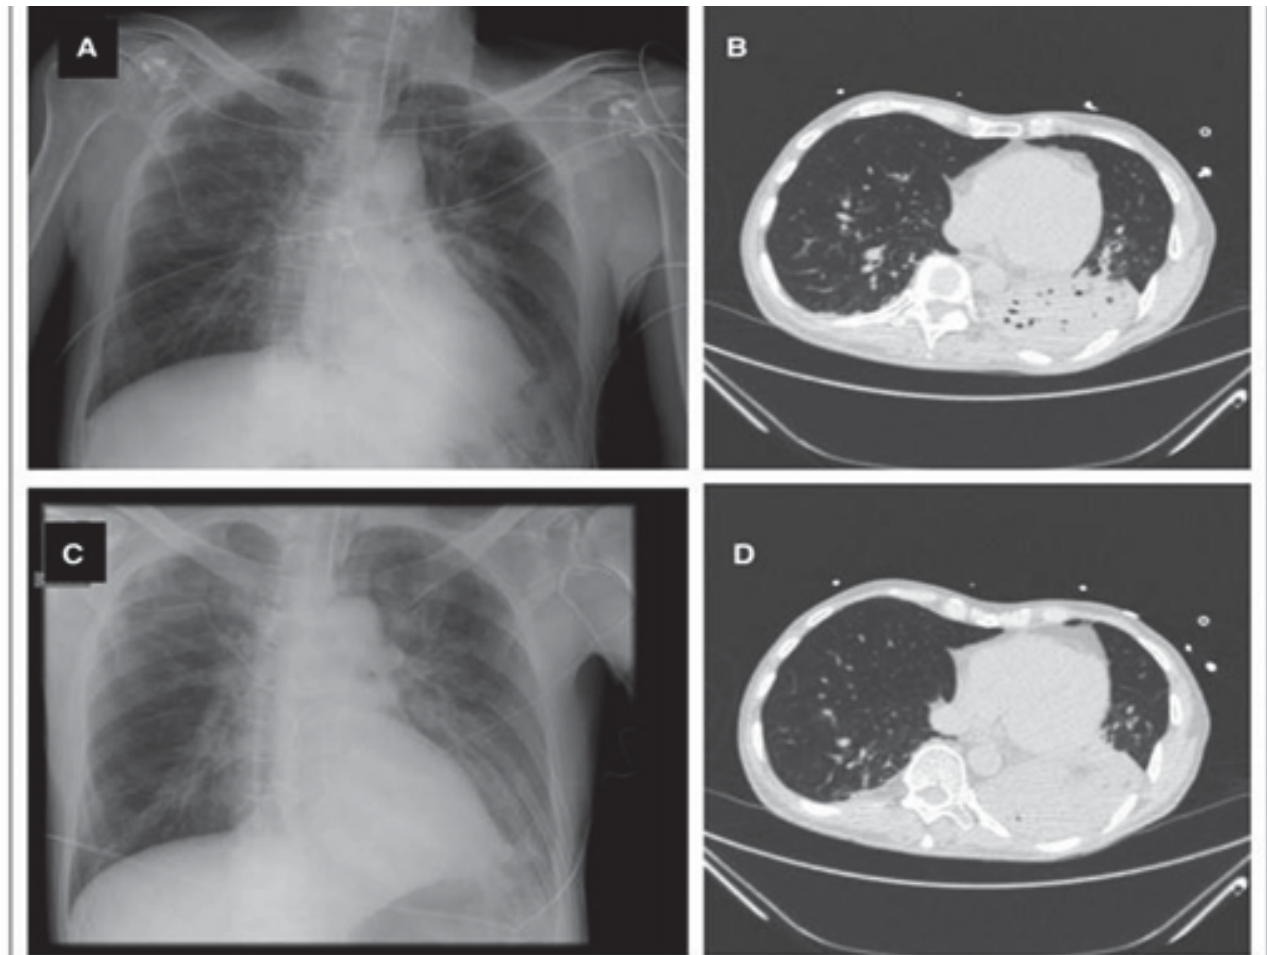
Chest X-rays and CT-scanofa65-year-oldmanpnemonia
